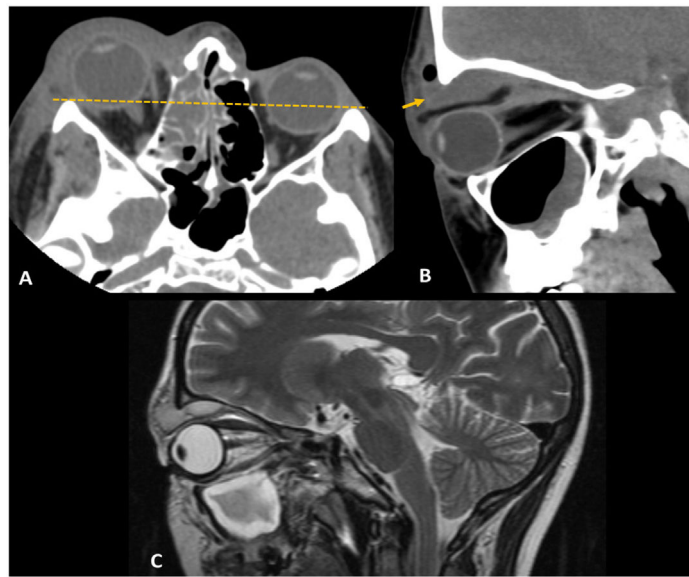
Orbital abscess: Axial (A) and sagittal (B) non-enhanced CT images, soft tissue window, present opacification of the left ethmoidal cells, associated to severe proptosis and a fluid collection with sharp angles with the orbital roof, in keeping with an orbital abscess. (C) Sagittal T2-weighted images of another patient shows a discrete fluid collection in the orbital roof (white arrow) associated to extensive orbital inflammatory changes and maxillary occupation (not shown).
